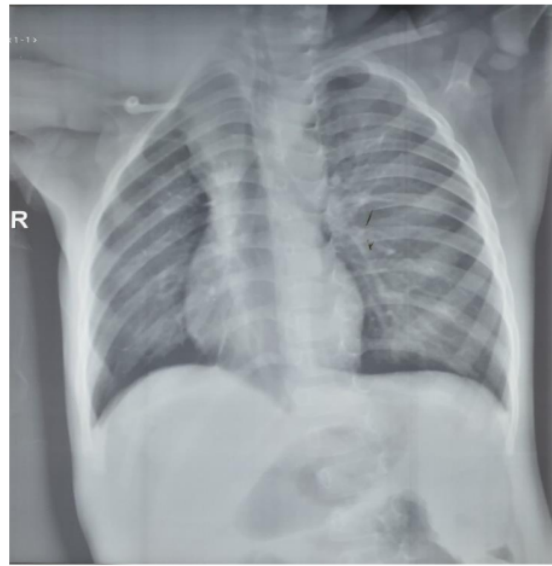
The chest x-ray revealed no cyst extension into the chest cavity and only minor tracheal deviation to the right
